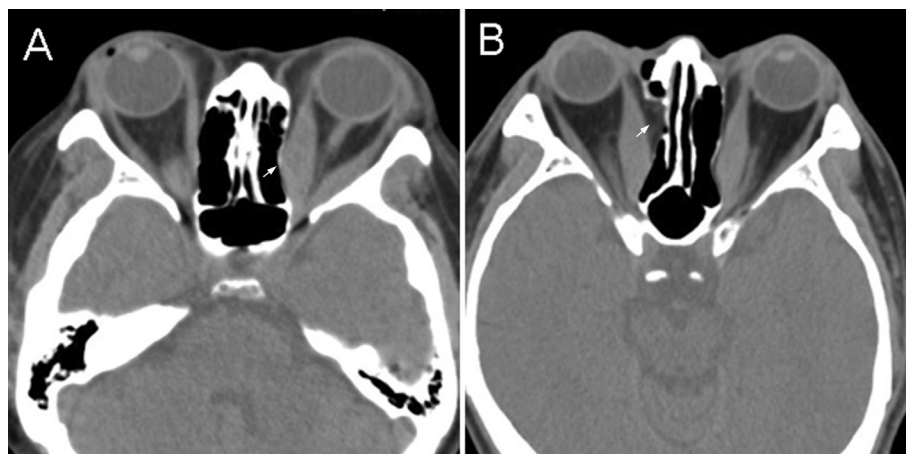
Representative computed tomography (CT) images of spontaneously decompressed orbit. Axial CT scans showing the flattened orbital wall with nasal displacement of the left medial wall (A) and the fracture with herniation of soft tissue in the right orbit (B). White arrows indicate decompressed orbit.
